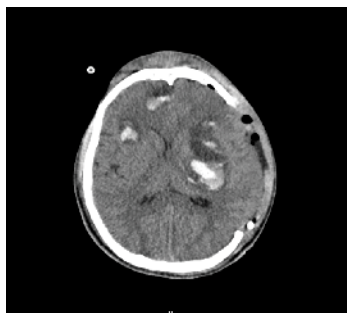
CT after decompressive craniectomy for left cerebral haemorrhages.
